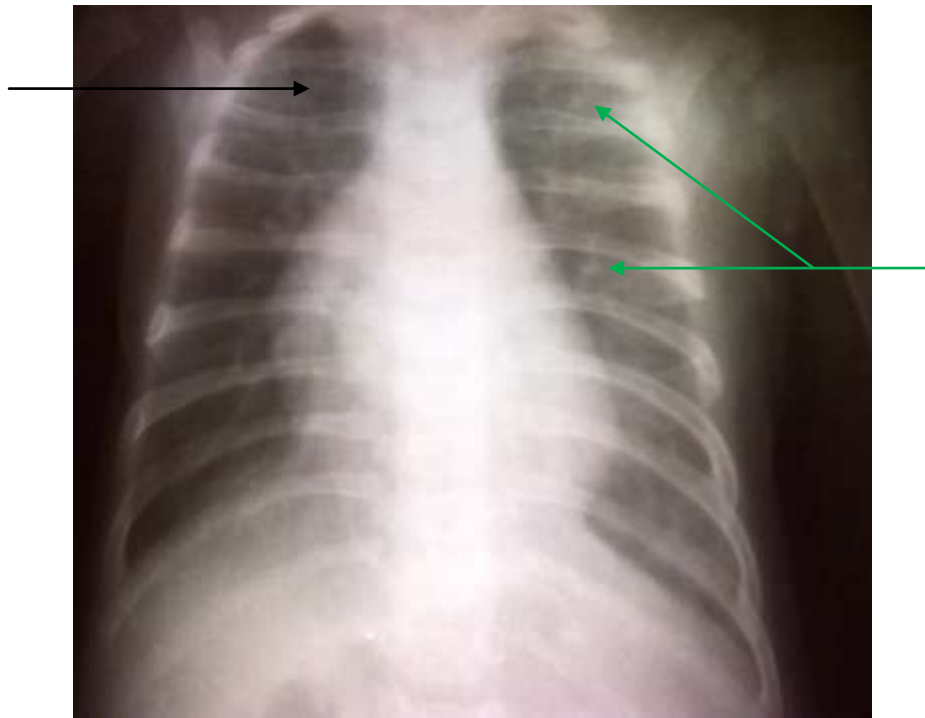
Chest radiograph. (Black arrow shows cystic change, whereas, green arrows point to reticulonodular lesions on the lung fields).
